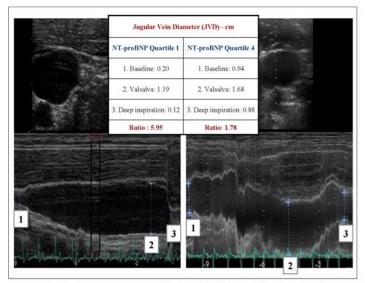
Jugular Vein Measurements. With the patient reclining and head and neck elevated at 45°, the internal jugular vein (JV) is identified and JV diameter (JVD) and its changes are measured continuously by M-mode ultrasound at rest in the expiratory phase (1), then during a Valsalva manoeuvre (2) and, finally, during deep inspiration (3). The ratio between maximum JV diameter during Valsalva and diameter at rest is calculated (JVD ratio). JVD changes and JVD ratio in different patients with HF are shown (on the left side, for a patient in the lowest NTproBNP quartile and on the right side for a patient in the highest NTproBNP quartile). The scale used is different in each panel.
